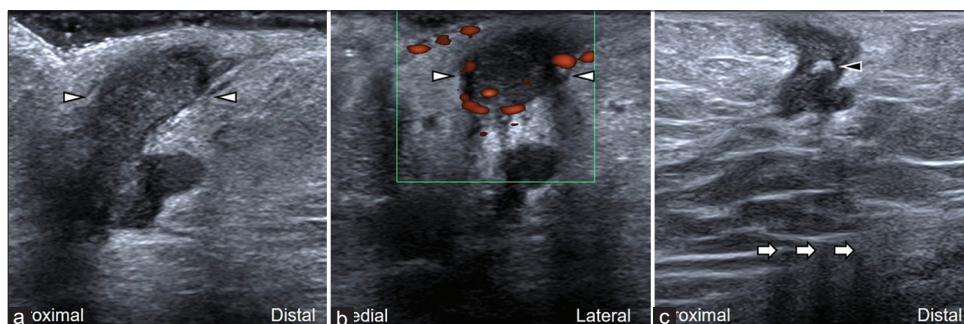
(a) The image was obtained by placing the transducer in the sagittal plane over the mass (arrowheads). (b) The image was obtained in the power Doppler mode showing hyperemia surrounding the mass. (c) The diverging artifacts (white arrows) behind the hyperechoic structure (black arrowhead) were observed
